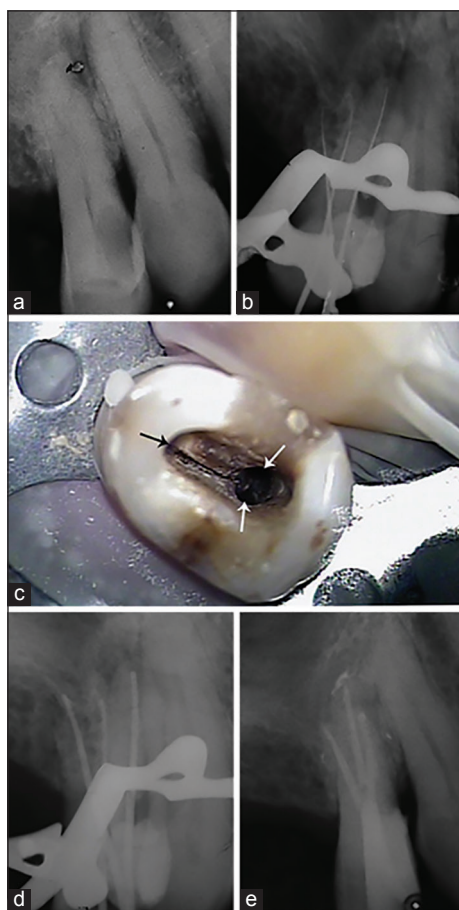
(a) Pre-operative IOPAR. (b) Initial working length IOPAR taken at a mesial horizontal angulation, revealing a double periodontal ligament space (distally) giving a suspicion for an extra root. (c) View of pulp chamber and root canal orifices under magnification. (d) Master cone radiograph. (e) Obturation radiograph
